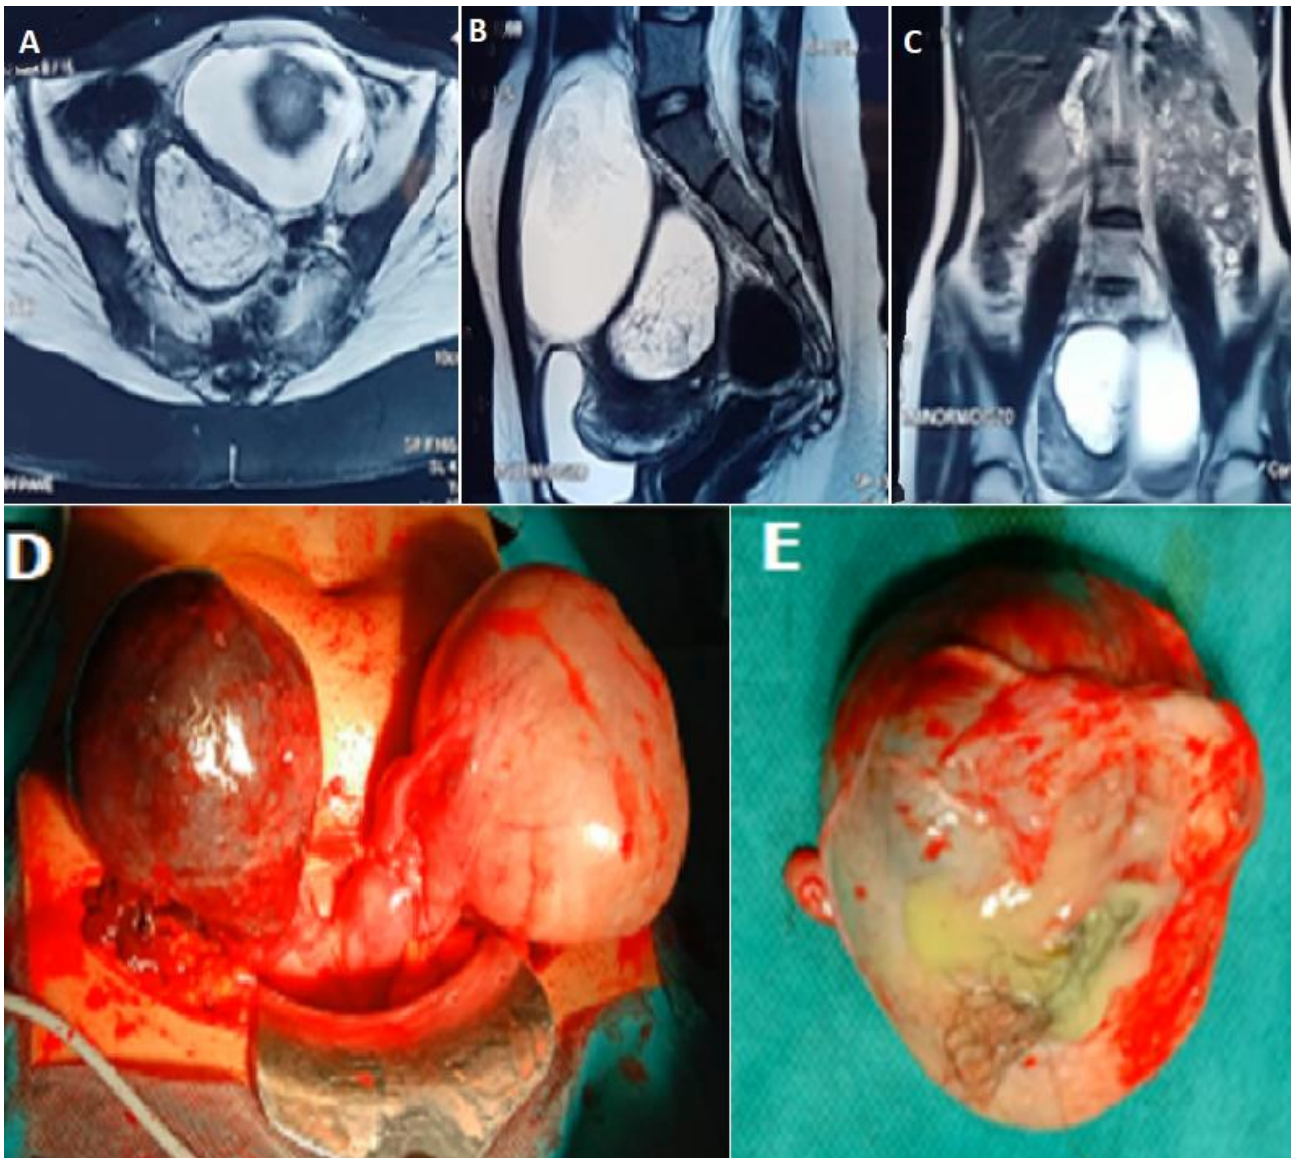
A) transverse pelvic MRI showing two bilateral ovarian cystics with torsion on the right and aspect of dermoid cyst on the left; B) sagittal pelvic MRI showing two bilateral ovarian cystics with torsion on the right and aspect of dermoid cyst on the left; C) frontal pelvic MRI showing two bilateral ovarian cystics with torsion on the right and aspect of dermoid cyst on the left; D) two large bilateral ovarian cysts with right ovarian ischemia and left dermoid cyst; E) left dermoid cyst after cystectomy
